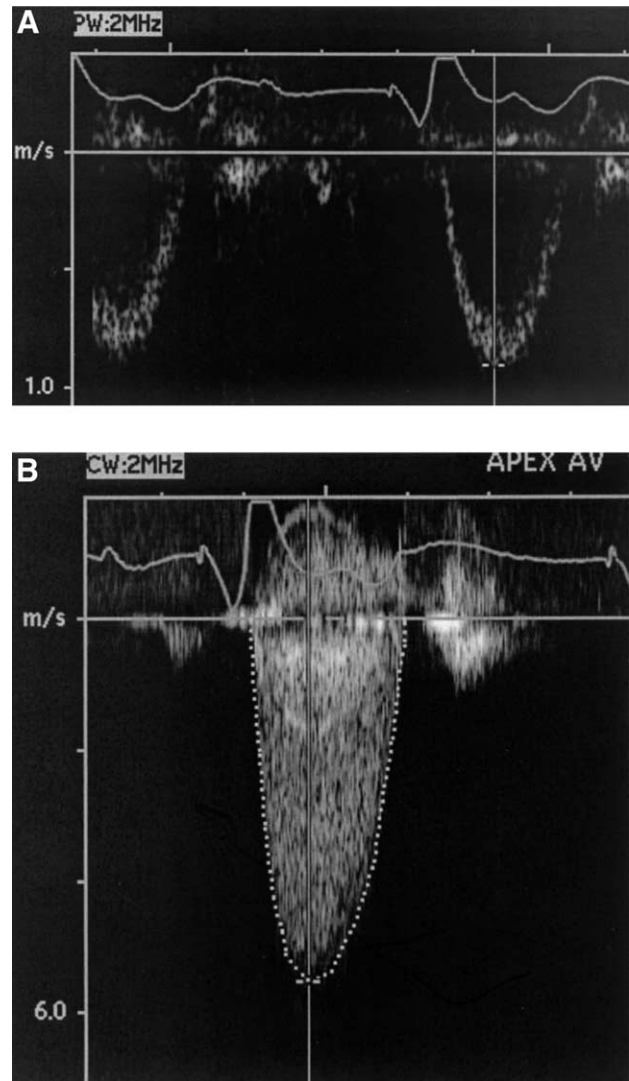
Doppler data needed for evaluation of aortic stenosis severity. (A) The left ventricular outflow tract velocity (LVOT) is recorded with pulsed Doppler from an apical approach with the sample volume positioned immediately proximal to the aortic valve. Note the smooth envelope of flow with a narrow band of frequencies at any time point and a clearly defined peak velocity of 0.9 m/s. (B) The aortic jet velocity is recorded with continuous wave Doppler from whichever window yields the highest velocity signal (in this case, an apical view). The maximum velocity of 5.6 m/s corresponds to maximum pressure gradient of 125 mm Hg and a mean gradient of 75 mm Hg. The LVOT to aortic velocity ratio is 0.16 and aortic valve area (measured LVOT diameter of 2.4 cm) is 0.7 cm².
